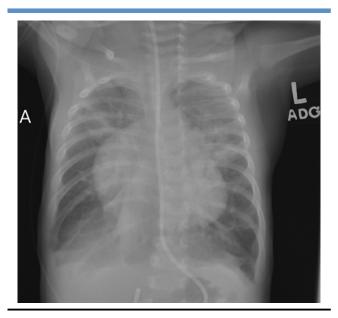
Chest radiograph of a 3-month-old female patient with trisomy 21 and unrepaired CAVC obtained on admission with cardiomegaly, shunt vascularity, lung hyperinflation, and new linear areas of airspace opacity representing atelectasis vs underlying superimposed pneumonia.
